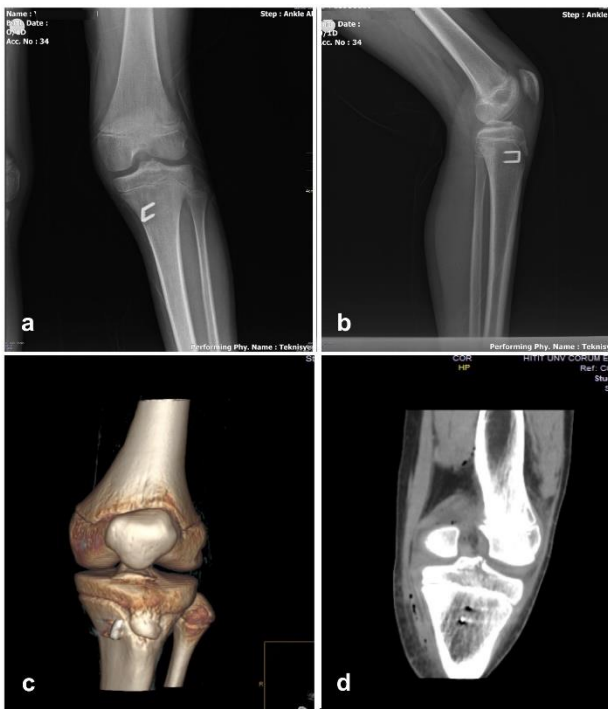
Postoperative images of the patient in Figure 1. a, anteroposterior X-ray image; b, lateral X-ray image; c, three-dimensional CT image; d, coronal CT image.
